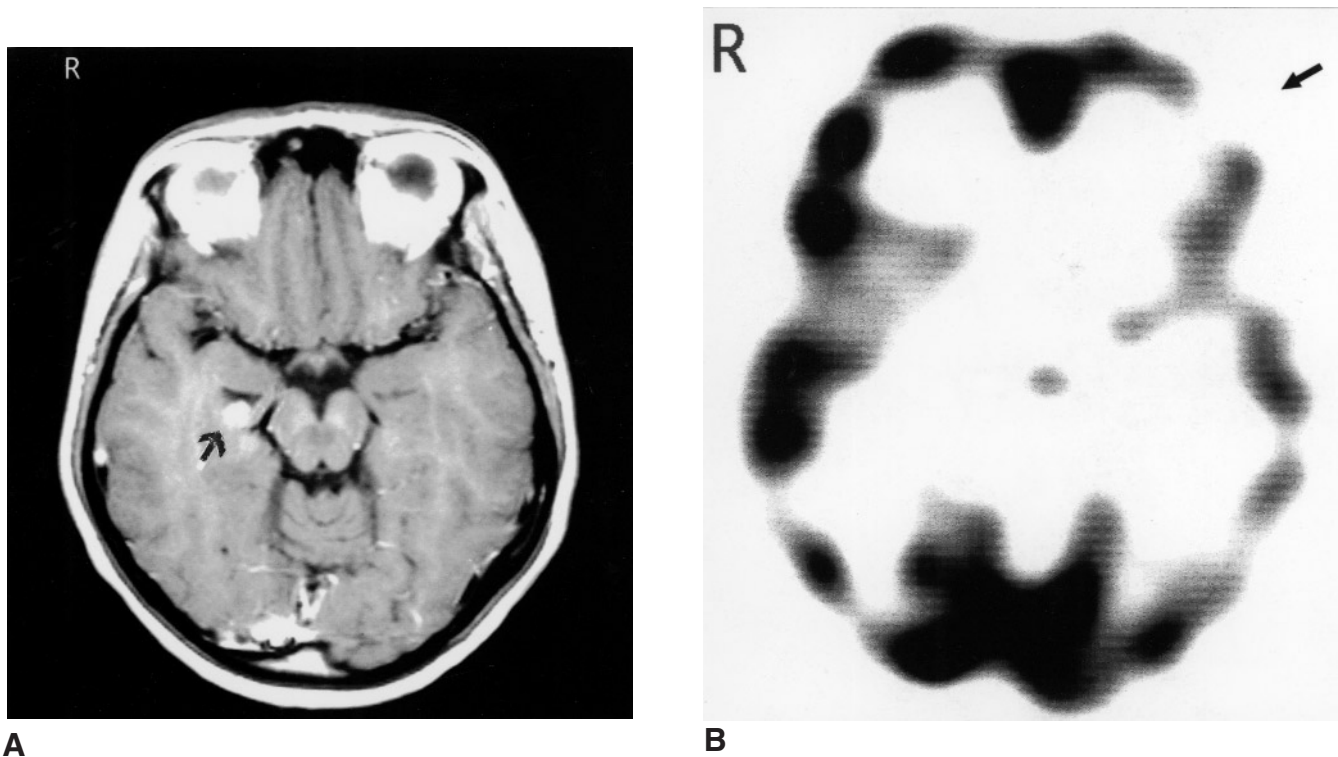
A 18-year-old girl with slight PFH on the right side and morphea on the trunk. A. MRI examination after contrast application shows a pathological focus in the right hippocampus. Enlargement of the subarachnoid space around the hippocampus and its hypoplasia (volumetrically proven) was also found. B. CBF-SPECT study shows decreased regional blood flow in the left frontal-temporal region. Angio-MRI showed lack of anterior communicating artery, and EEG showed slow waves in the region of the left hemisphere. Neurological examination was normal.
